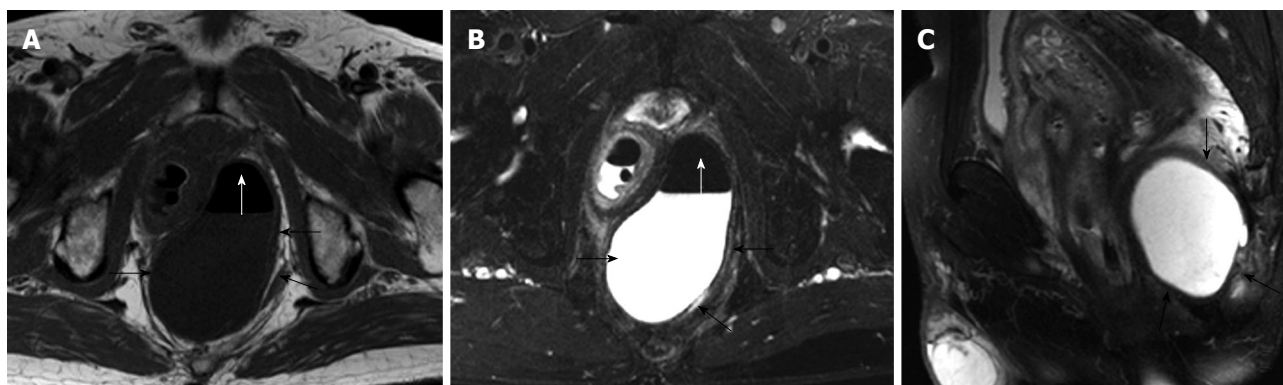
Dermoid cyst in a 63-year-old man, who was misdiagnosed as having abscess. Axial T1-weighted (A), T2-weighted fat-suppression (B) and Sagittal T2-weighted (C) magnetic resonance (MR) images show a thin regular peripheral rim (black arrows) circumscribing a retrorectal cyst and containing some air (white arrows). The cyst lesion extends to the left ischiorectal fossa, and is hypointense on T1-weighted (A) and hyperintense on T2-weighted MR images (B, C).
